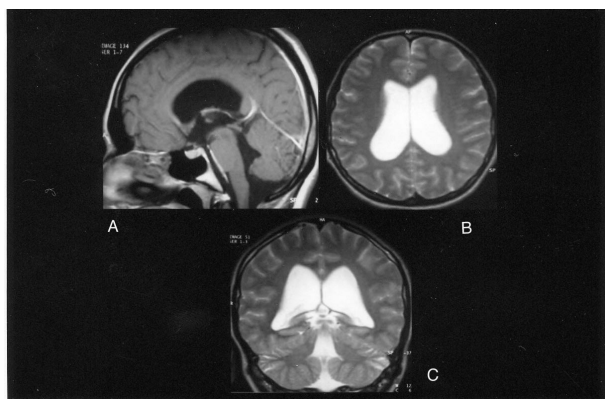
Sagittal T1-weighted with contrast enhancement (Fig. 1A), axial T2-weighted (Fig. 1B) and coronal T2-weighted (Fig. 1C) MR images demonstrate communicating hydrocephalus without neural parenchymal lesion or pathological contrast enhancement. Note wide posterior fossa cisterns, and fourth and third ventricles.
